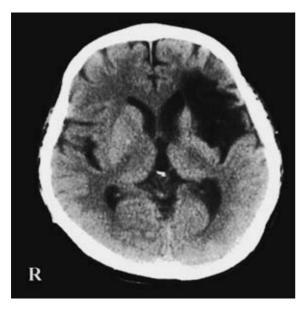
Brain CT scan of the patient from the initial examination shows cerebral infarction on the left frontal lobe, left basal ganglia, and left insula.
